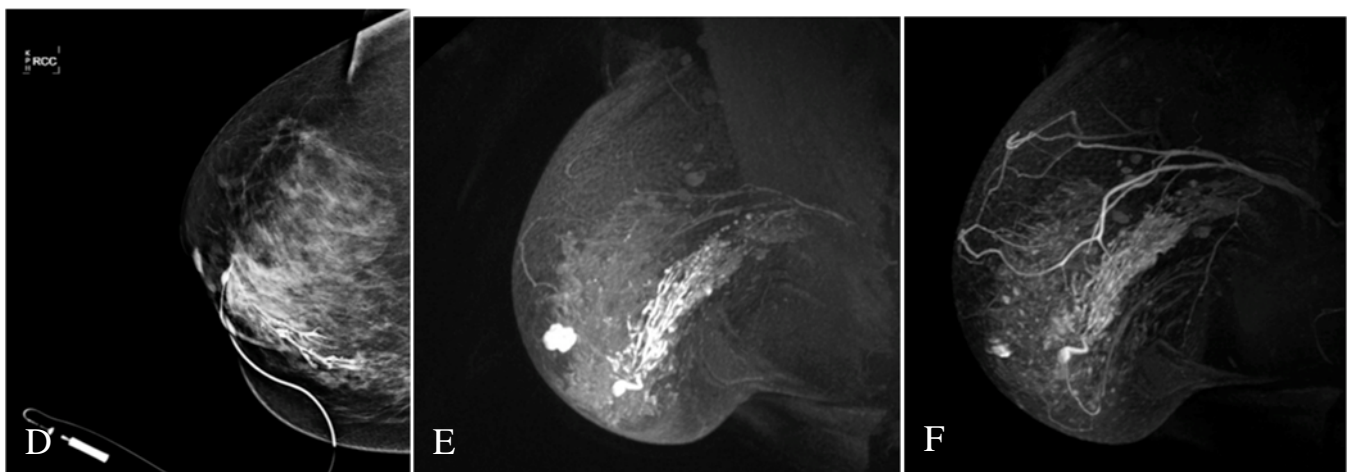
D-F. DCIS on MRI that was occult on mammography, ultrasound and ductography.
